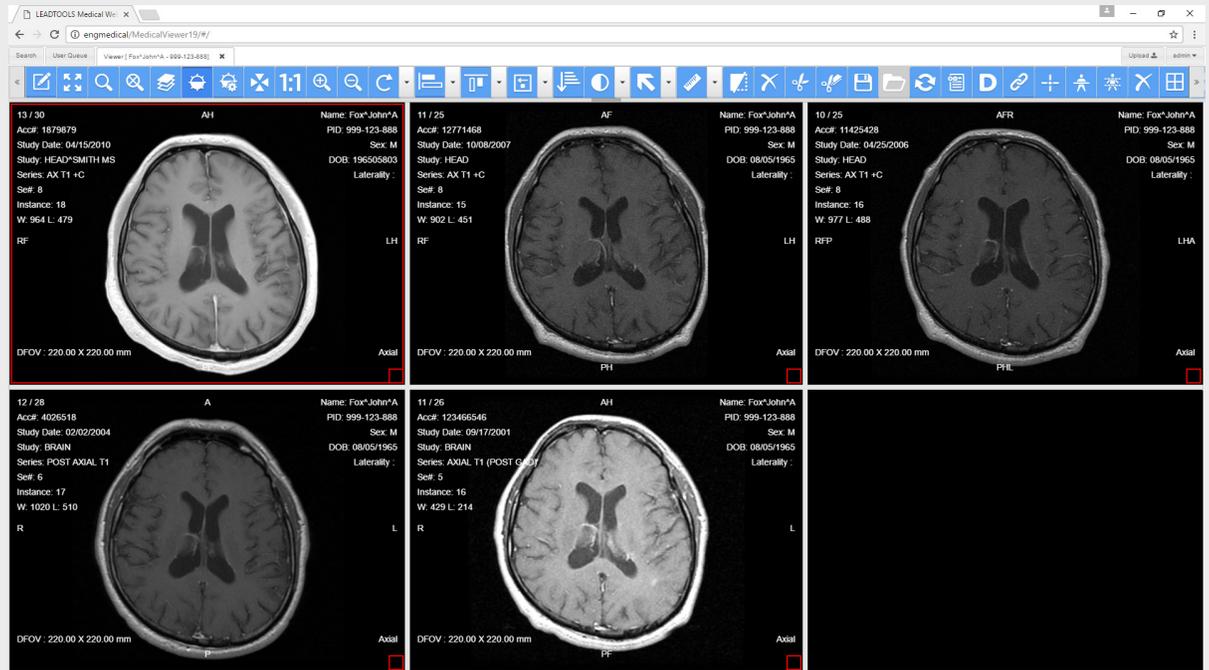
Using a Hanging Protocol with up to 5 priors for an MRI patient with many prior studies.
